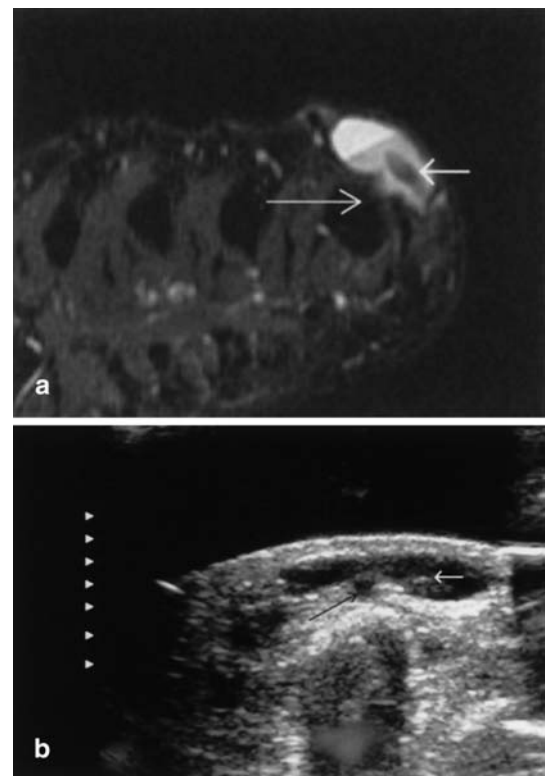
Synovial cyst. a Axial short time inversion recovery (STIR; TR/TE/slice thickness: 3640 ms/36 ms/3 mm, 140 ms inversion time) MR image. b Ultrasound image. Lobulated well-circumscribed hyperintense and anechoic lesion arising from the joint. The stalk (long arrow) of the cyst and the fibrous component (short arrow) are conspicuous
